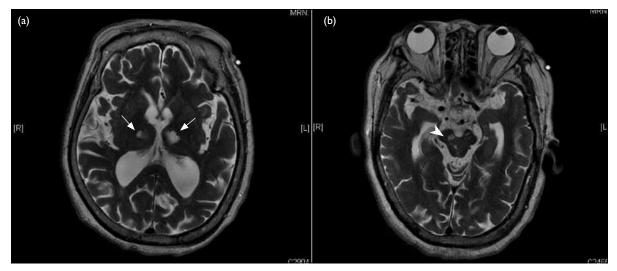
T2-weighted axial brain magnetic resonance images showing (a) bilateral hyperintense signals over the medial part of each thalamus (arrows), and (b) hyperintense signals over the right crus cerebri (arrowhead) at the level of the midbrain
